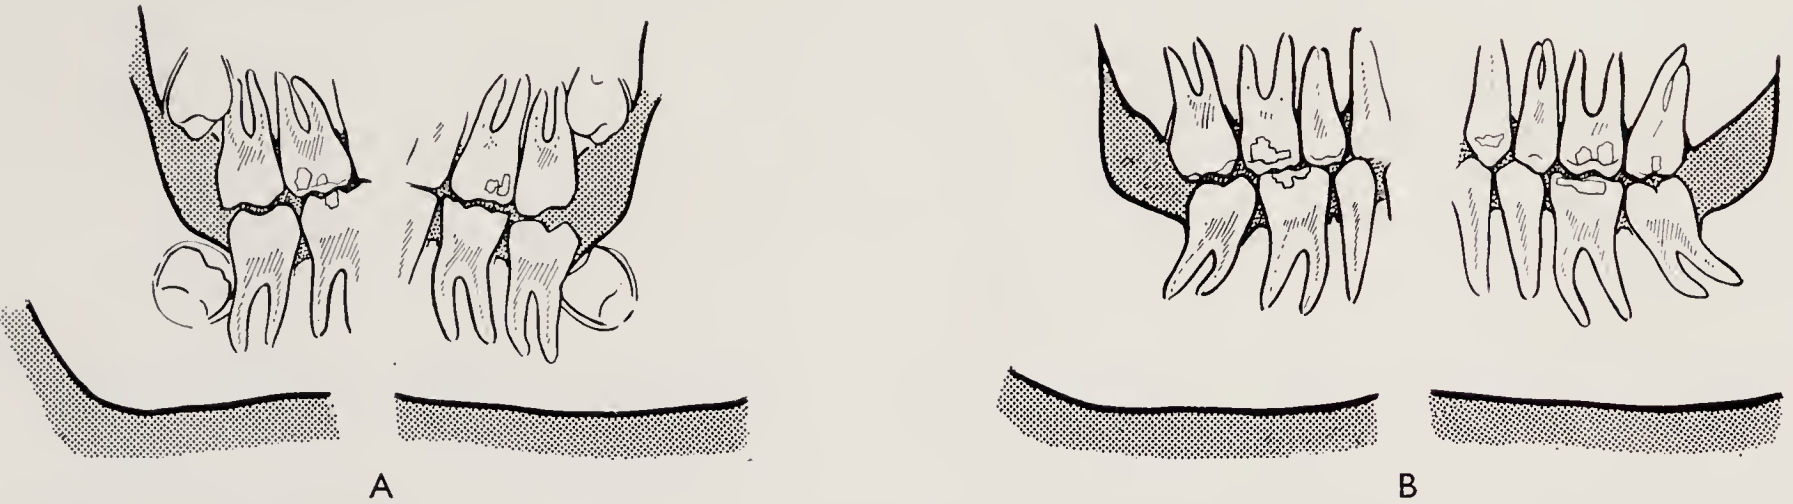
Radiographs taken: A, At 11 years of age, 1 year before extraction of second molars; B, At 17 years of age.
